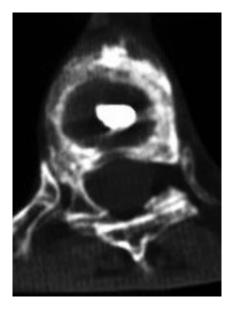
CT leak toward the disk.
